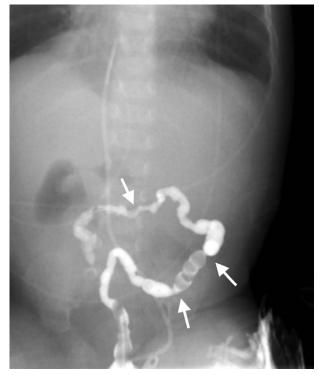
Ileal atresias detected by lower gastrointestinal tract radiography in the first month of life, after the first operation.
